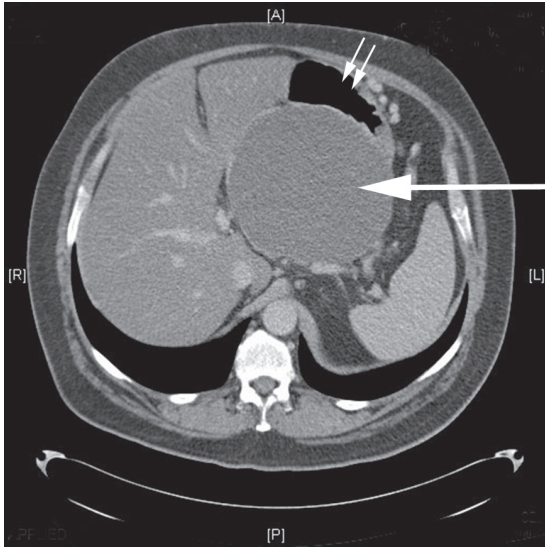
CT scan of a transverse section through the abdomen showing a large pancreatic pseudocyst (single large arrow) displacing the stomach (double arrow).
